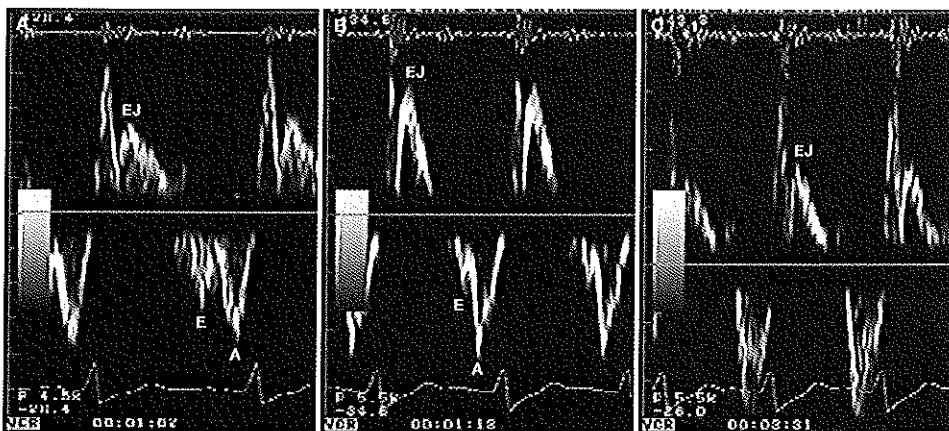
Pulsed wave-Doppler tissue sampling of the right ventricular free wall at rest (panel A), low dose ( $10 \mu\text{g}/\text{kg}/\text{min}$ ) (panel B) and peak dobutamine stress (panel C) in subject with right coronary artery narrowing (Group 2). Ejection phase velocity does not increase from low dose to peak dobutamine stress. EJ = ejection phase, E = early diastole, A = late diastole.
